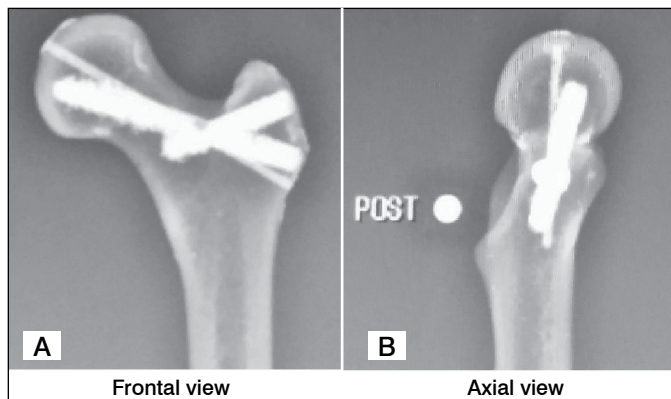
Radiographic images of the synthetic model after completely filling the holes.
